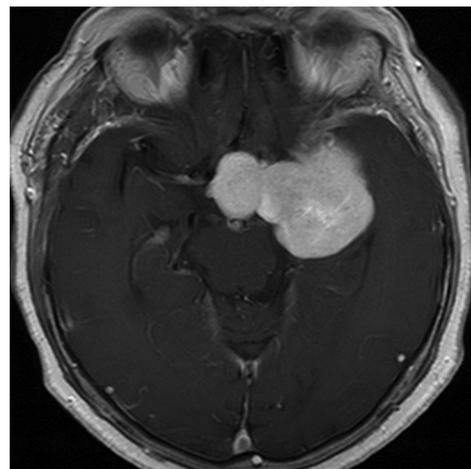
Axial T₁-weighted gadolinium-enhanced MR image reveals a dumbbell-like mass with strong and homogenous enhancement in the left cavernous sinus.
